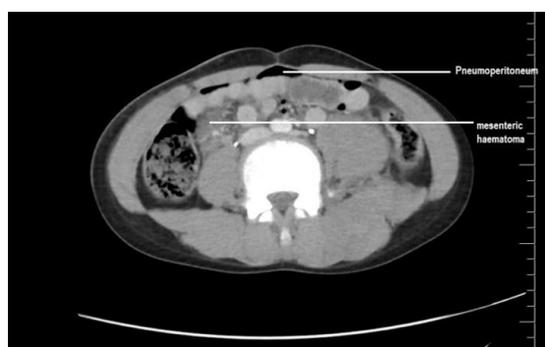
Coronal section of contrast CT of abdomen showing mesenteric hematoma and pneumoperitoneum.
